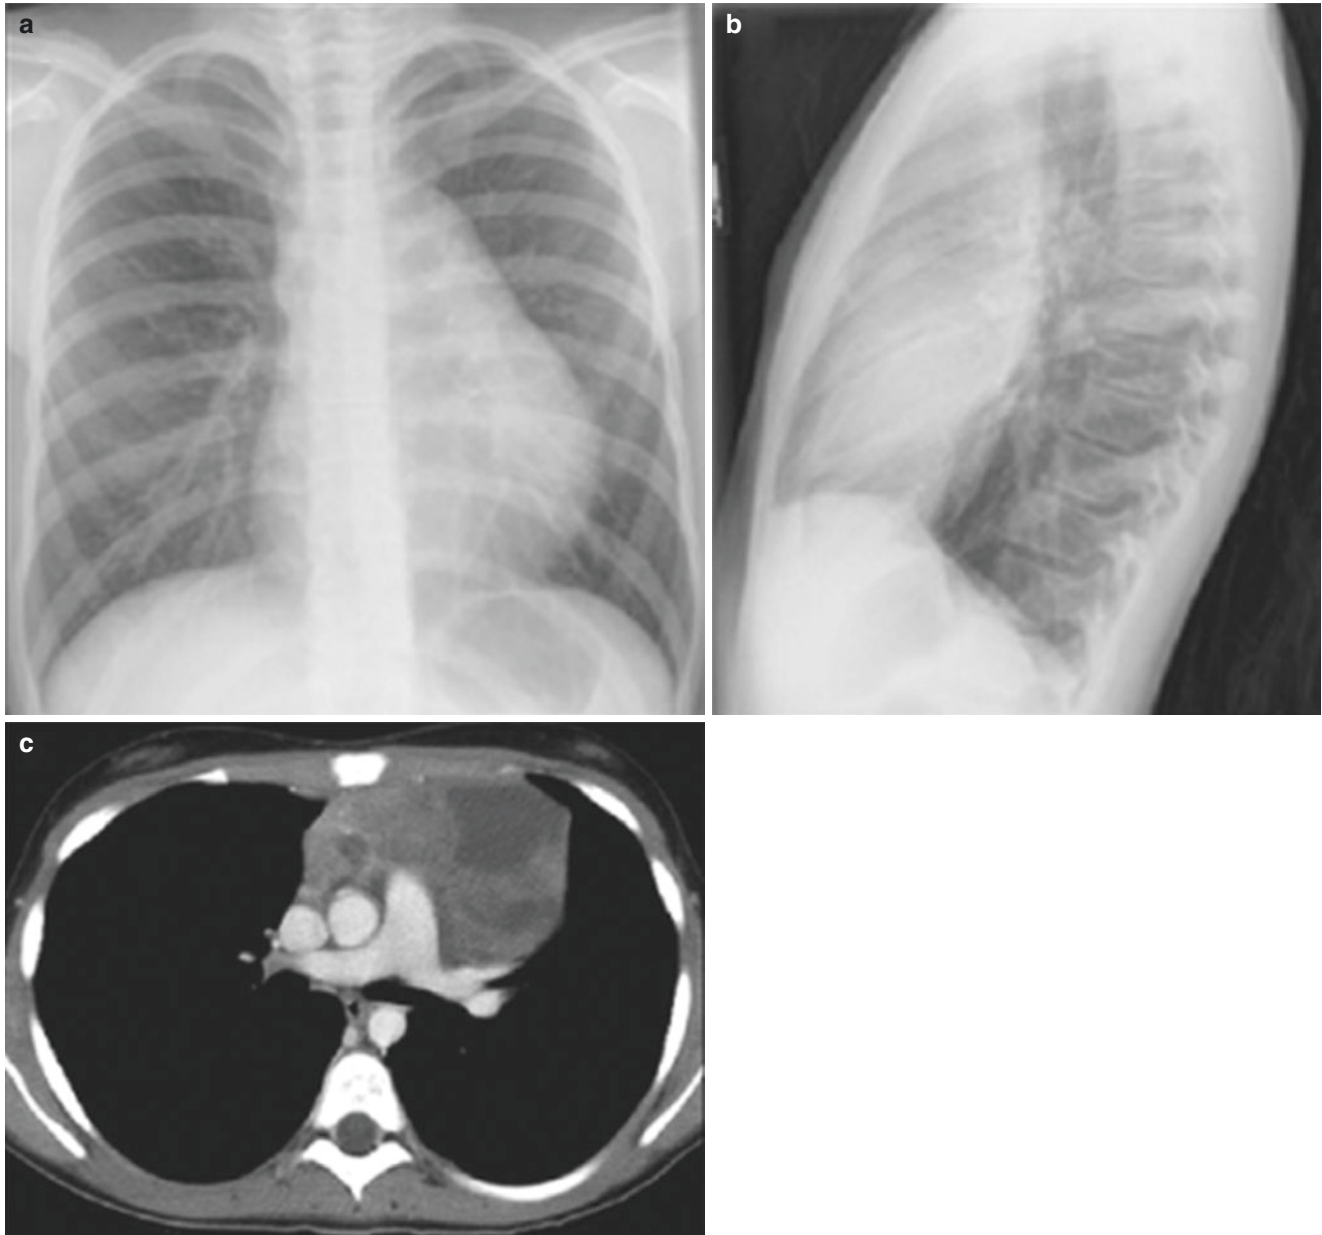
An 11-year-old girl who presented with shortness of breath and weight loss. (a) Frontal chest radiograph shows a large mediastinal mass. (b) Lateral chest radiograph demonstrates the location of the mediastinal mass to be within the anterior mediastinal compartment. (c)
